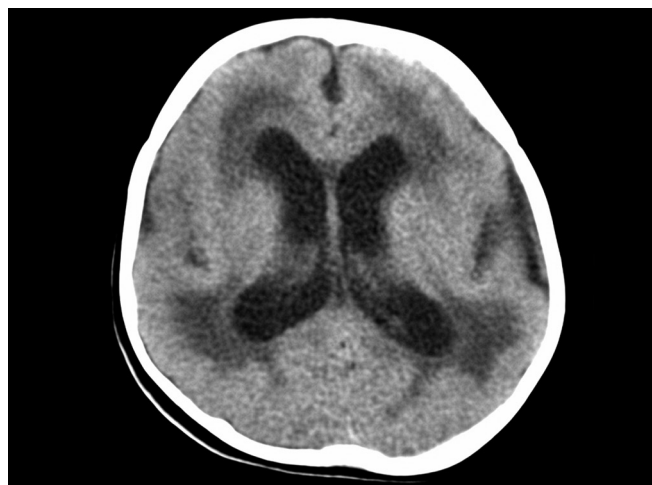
CT head of a child with lissencephaly showing smooth and thickened cortex. Underlying white matter is abnormally hypodense and ventricles dilatation is apparent
